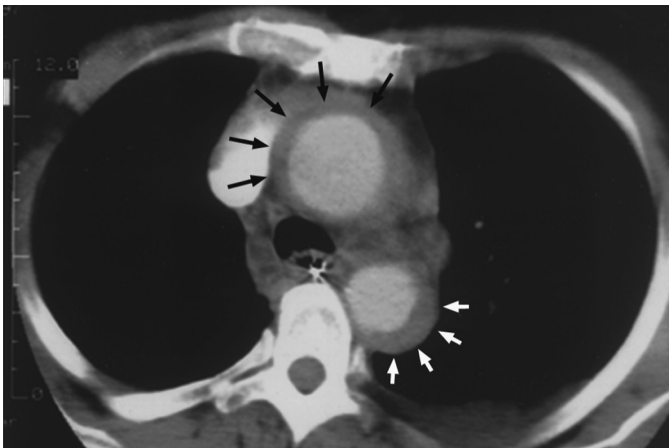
Contrast-enhanced CT scan demonstrating type A IMH of the aorta. Note the circumferential hematoma involving the ascending aorta (black arrows) and the crescentic hematoma involving the descending aorta (white arrows).
